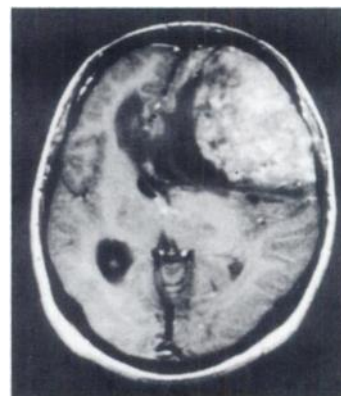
Gd-DTPA enhanced brain MR image. There was inhomogeneous enhancement in the tumor with less enhancement at the anterior and medial portion.
